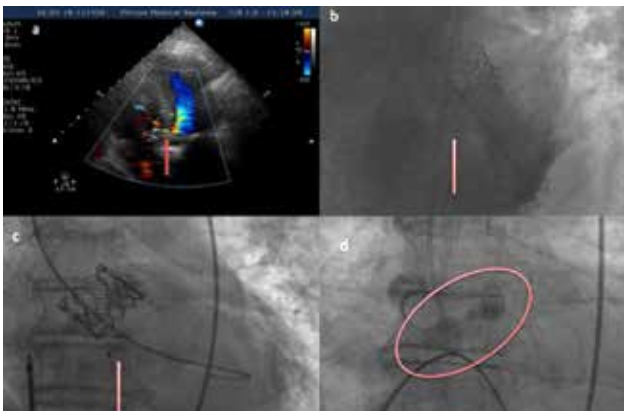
(A) Color doppler depict VSD shunt. (B) Intense contrast flow from left-to-right ventricle. (C) VSD closure device. (D) Dens calcific aortic valve. Left-to-right shunt, muscular VSD occluder and dens calcific aortic valve
